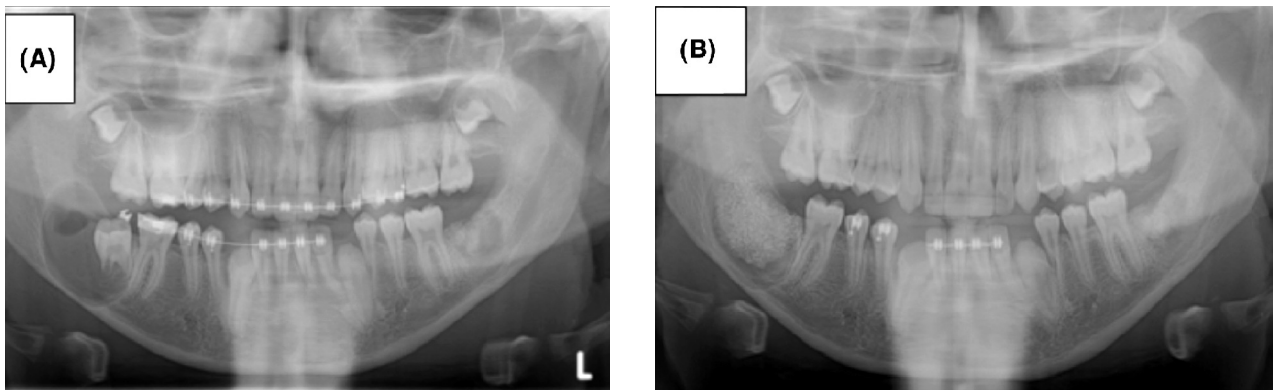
Pre-operative panoramic radiographic view (a). 6month post-operative panoramic radiographic view (b) shows area of radio-opacity representing Fisiograft grafted materials s surrounded by radiolucent zones.
